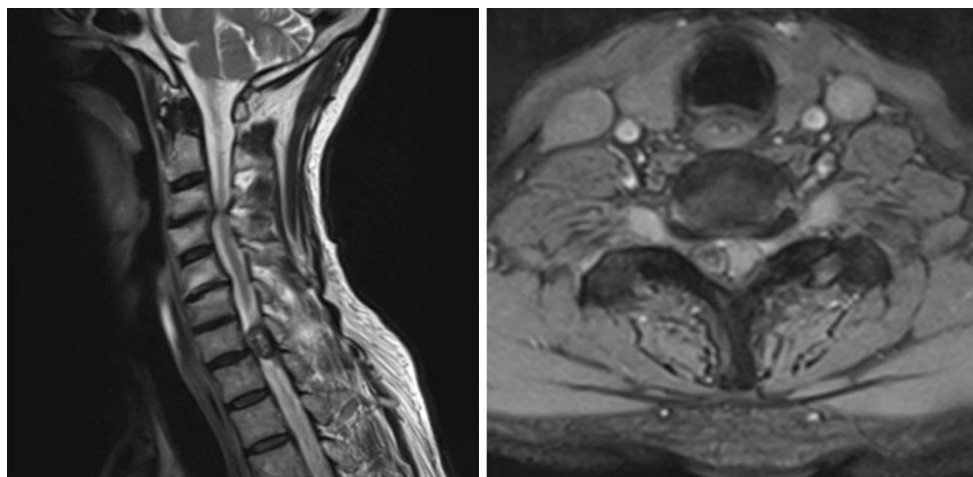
Parasagittal and axial MRI showing the cyst and its relationship with the spinal cord
